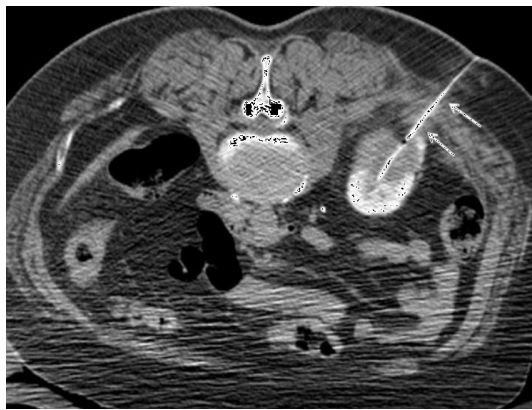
(a): Percutaneous treatment of a urinary leak with fibrin glue. Non-enhanced axial CT image showing the probe positioned in the lower third lesion of the left kidney.
